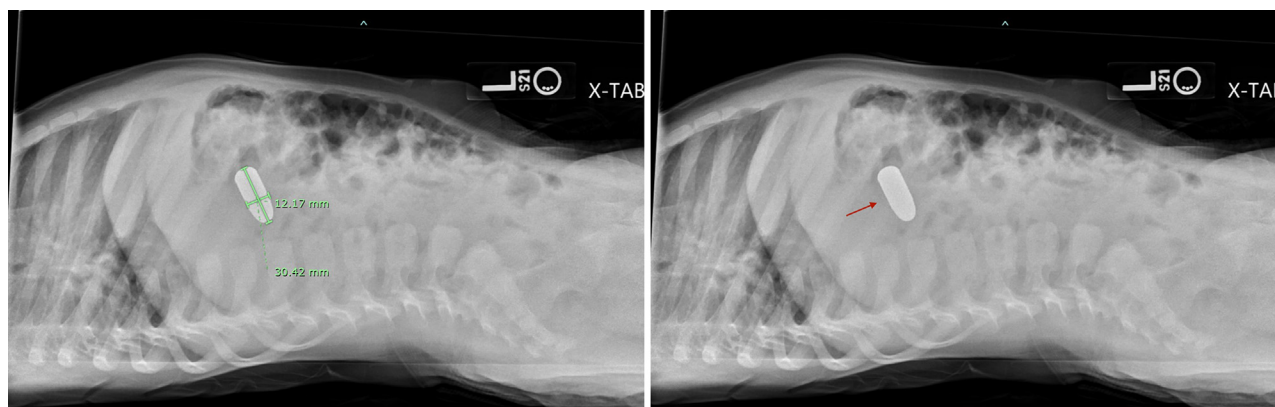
A subsequent lateral cross-table abdominal radiograph identified a radiopaque foreign body measuring 1.2 cm × 3.0 cm without evidence of pneumatosis, portal venous gas, or pneumoperitoneum.
